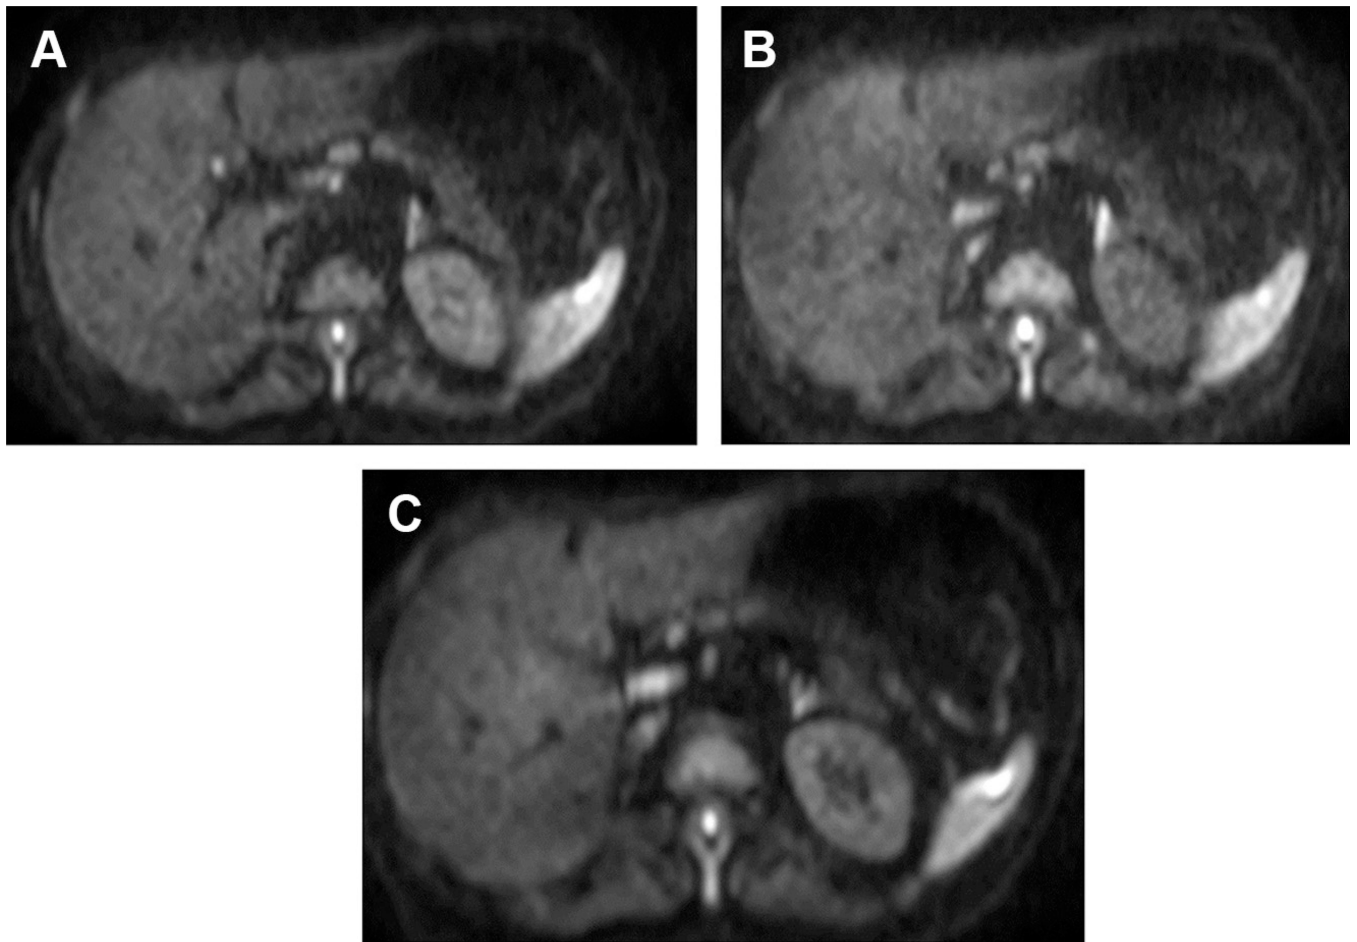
Techniques of respiratory synchronization in DWI of the liver. Notice different SNR and acquisition time in (A) breath-hold (acquisition time: 120 seconds; 20 seconds per breath-hold), (B) free-breathing (acquisition time: 80 seconds), and (C) respiratory trigger (acquisition time: 220 seconds) acquisitions.
